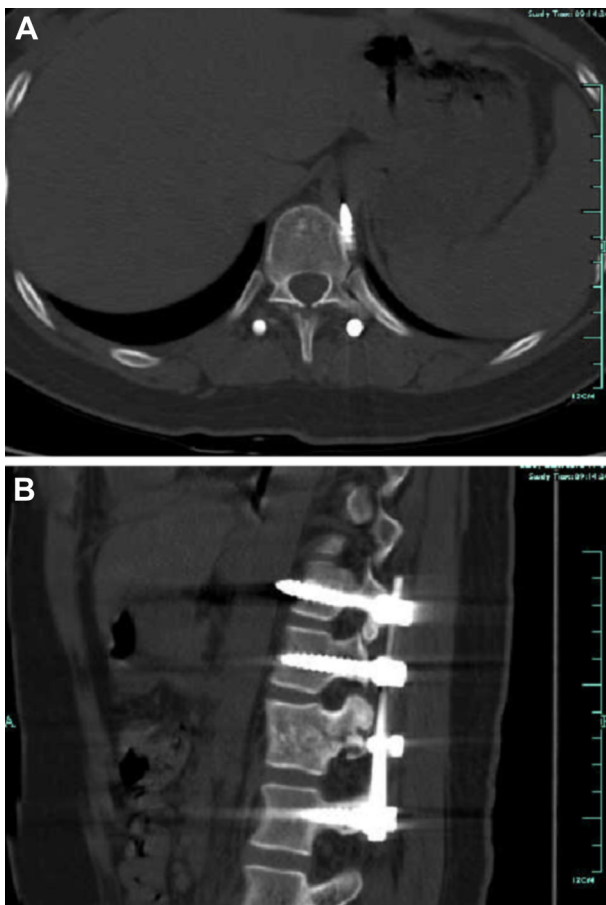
Noncontrast computed tomography scan demonstrates that the left T11 pedicle screw has caused an impingement on the posterior thoracic aortic wall.
